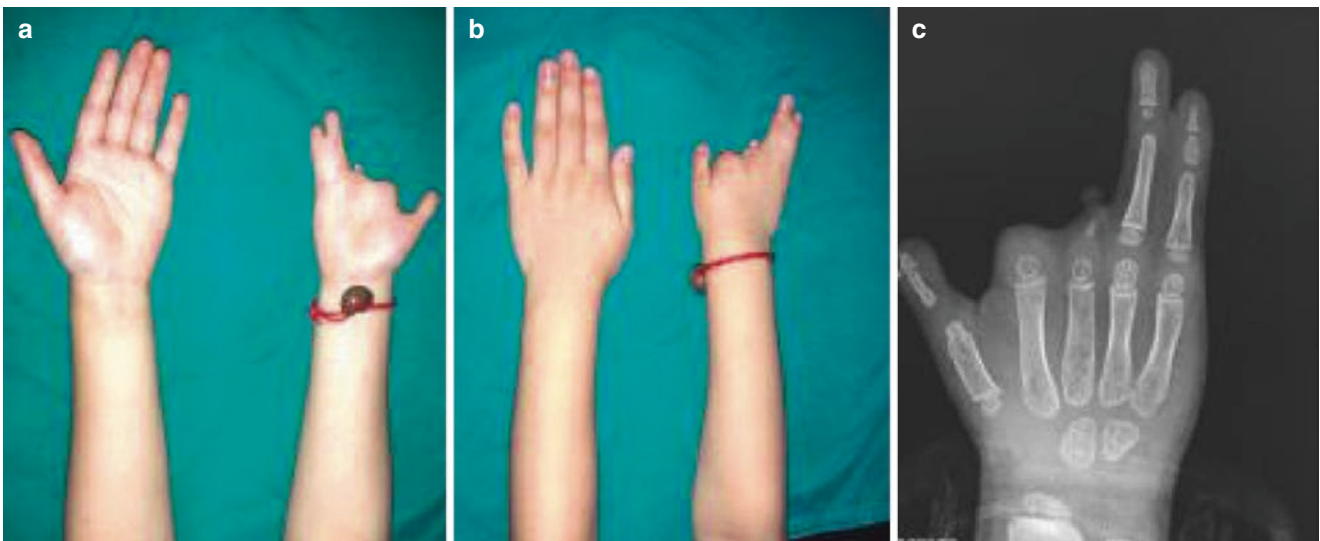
Case two. (a, b) Hand appearance. (c) X-ray findings
